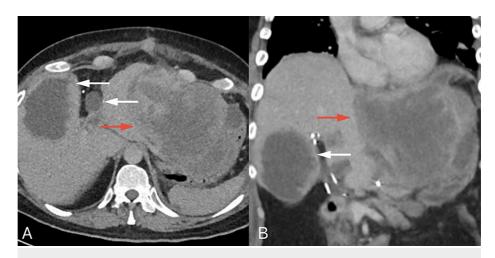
CT scans images a month after the second cytoreductive surgery
